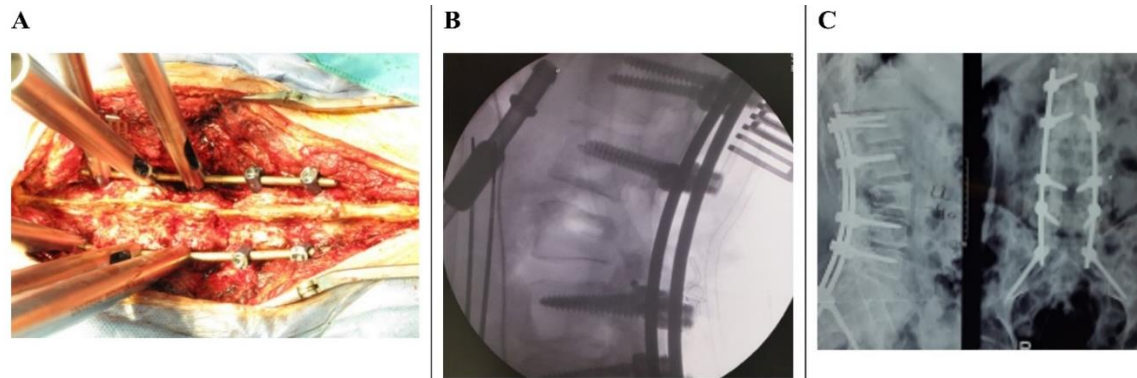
Closure of the osteotomy and restoration of posterior bony contact. A, B) After wedge resection, the osteotomy is gradually closed by controlled compression until the remaining laminae and spinous processes come into direct contact without a residual posterior gap, promoting contact between the posterior spinal elements; C) Standing anteroposterior (AP) and lateral radiographs obtained one year after surgery demonstrate maintenance of sagittal correction and stable instrumentation.
